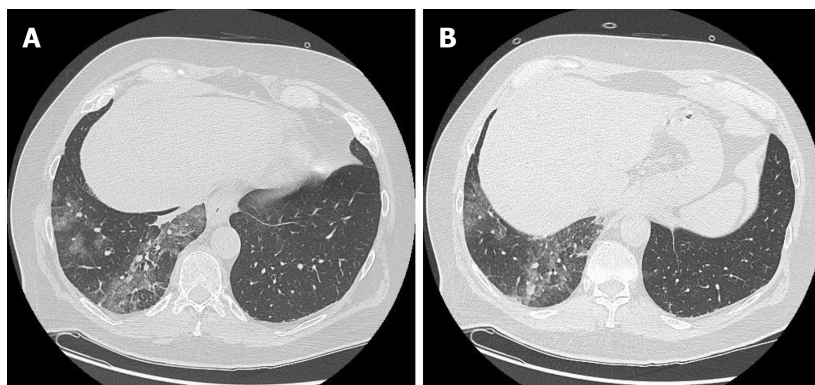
A 63-year-old man who presented to the emergency room for abdominal pain and no significant alterations on abdominal computed tomography. A: Computed tomography scan with pulmonary window at the level of lung inferior lobes (included in the volume acquisition) shows the presence of ground-glass opacities and crazy-paving pattern in the right side; B: Computed tomography scan with pulmonary window at lower levels of lung inferior lobes always exhibited ground-glass opacities and crazy-paving pattern in the right side.
